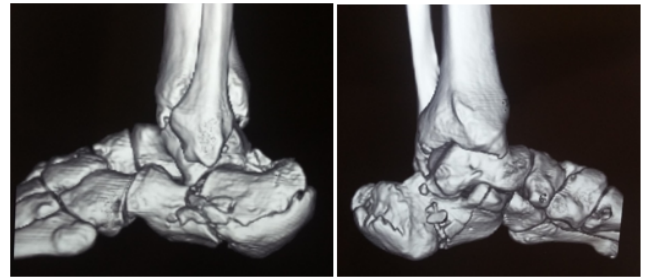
CT 3D virtual reconstruction of bone
